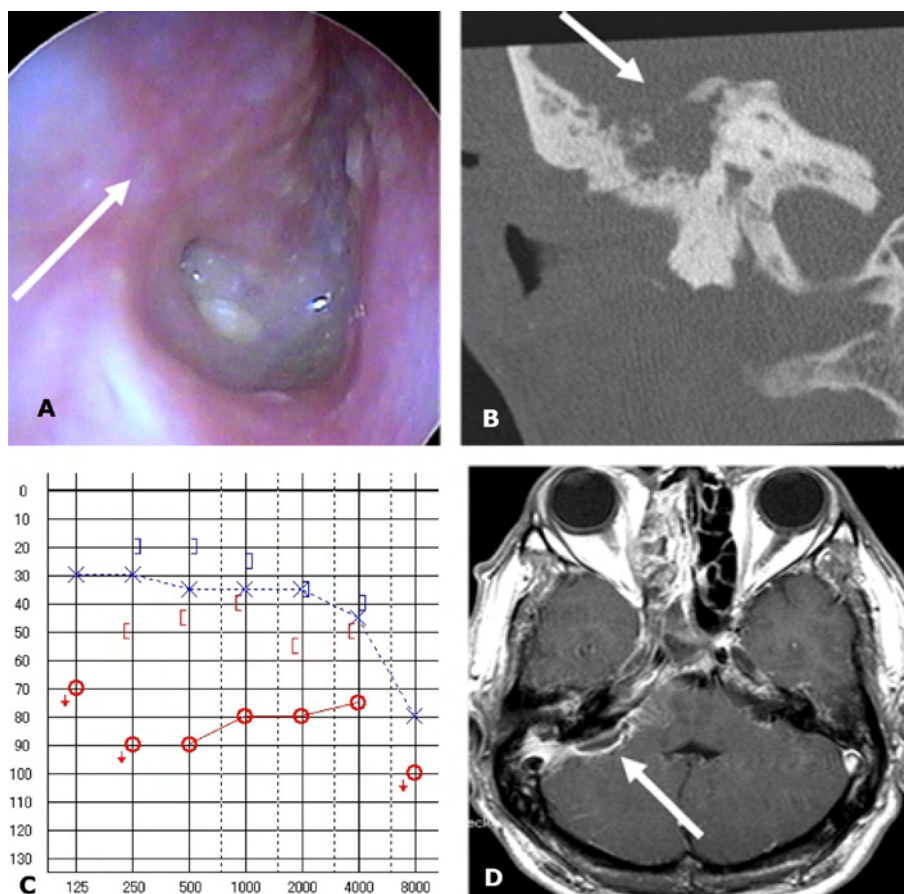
A. A white debris was observed. The swelled posterior wall of the external auditory canal (arrow). B. Coronal section CT. Bony destruction in the right tegmen (arrow). C. Audiogram showed right mixed hearing loss. D. Axial section MRI. Epidural abscess in front of the right cerebellar hemisphere (arrow).
